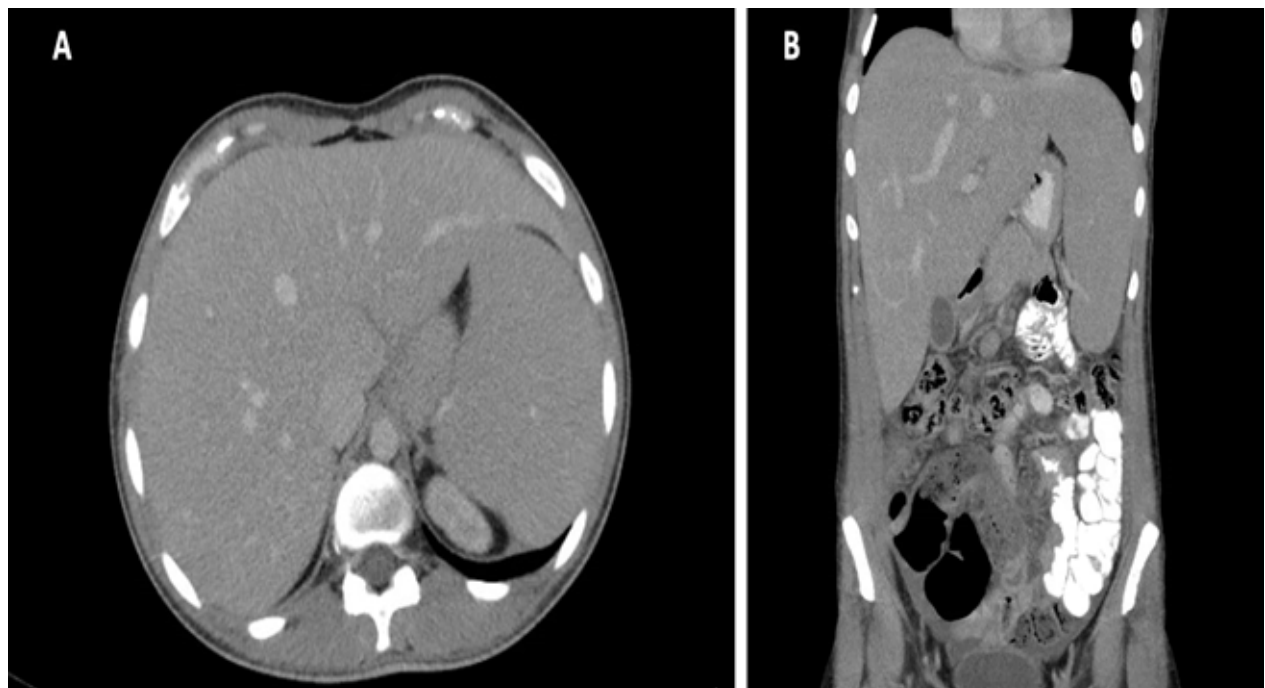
Computed Tomography (CT) scan with intravenous and oral contrast showing hepatosplenomegaly, poorly defined retroperitoneal and mesenteric nodularity, and possible mesenteric infiltration, mural thickening, and dilation of the terminal ileum and thickening of the cecum and proximal ascending colon with intussusception and possible obstruction.
